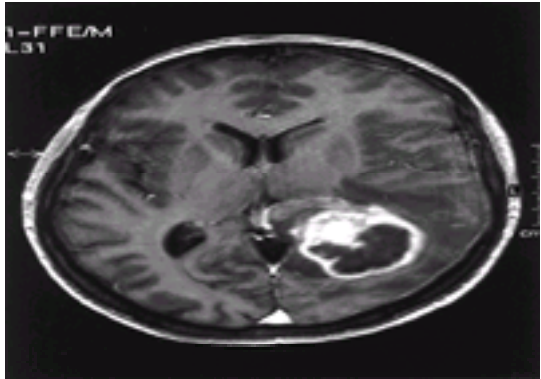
Gliosarcoma. Axial T₁-weighted gadolinium-enhanced MRI of a left parieto-occipital tumor with mass effect on the corpus callosum and obliteration of the normal contours of the lateral ventricle on that side. There is an irregular rim of enhancement with decreased central signal, suggestive of extensive necrosis. The radiographic appearance is similar to that of glioblastoma.
